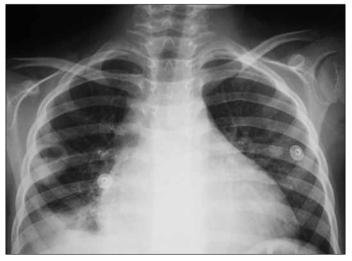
A cavitary lesion (2×2 cm) with an air-fluid level in chest X-ray
